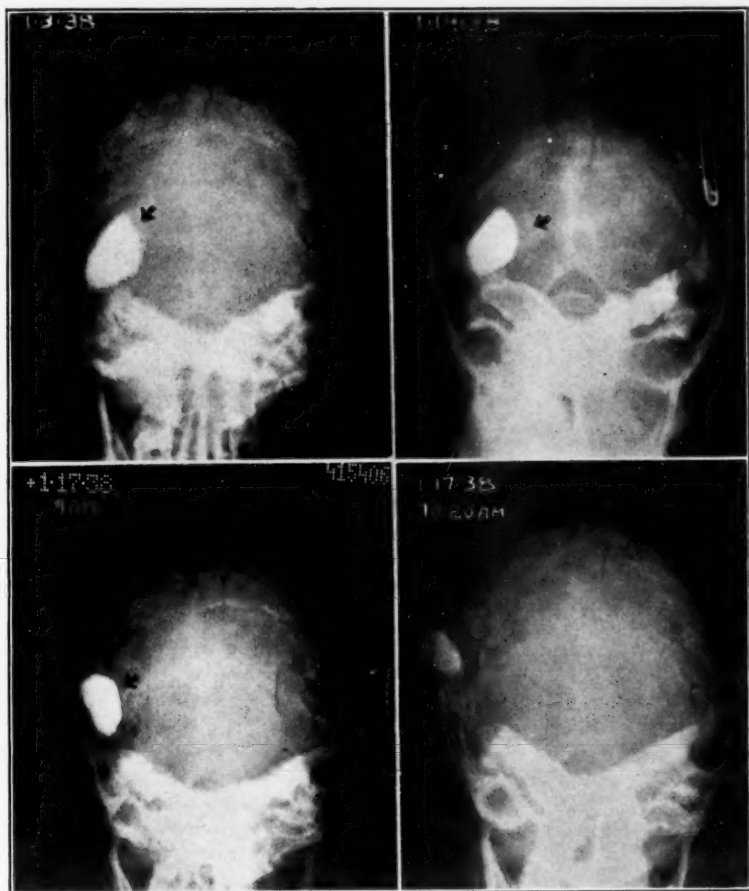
Migration and extrusion of a deep-seated abscess. The first roentgenogram was taken seventy-two hours after the instillation of colloidal thorium dioxide. The arrow points to the capsule, which was well shown on the original films.
